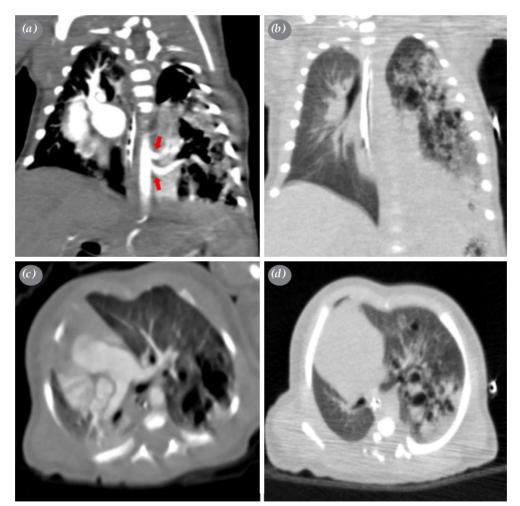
Computed tomography angiography demonstrating. (a) The vascular anatomy of the two feeding arteries (red arrows), (b) multiple small cystic lesions in the left lung at coronal section, (c) Pulmonary arteries with cystic lung lesion in the left lobe with two systemic arteries originating from the thoracic aorta, (d) Small cystic lesions with consolidation in the left lung at axial section.
